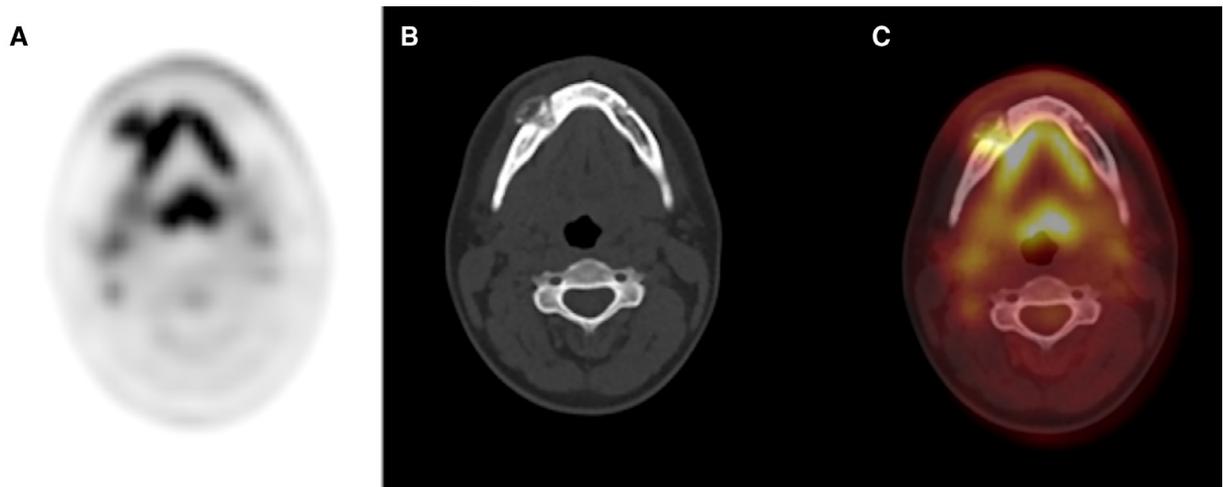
Axial positron emission tomography (PET) (A), computed tomography (CT) (B), and fused PET/CT (C) images show the hypermetabolic expansile lytic bone lesion in the body of the right hemi-mandible.
